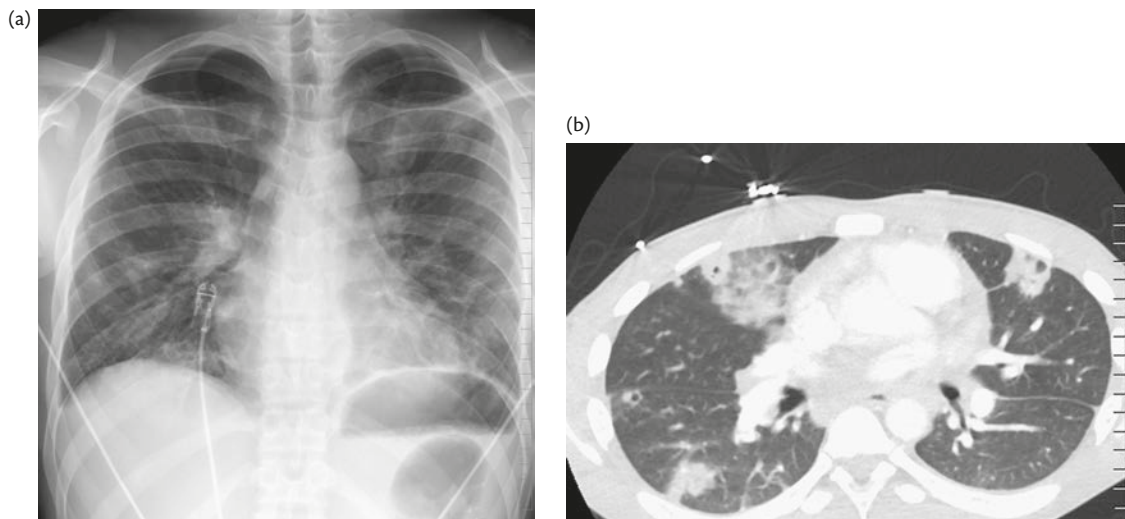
Case 6. (a) X-ray; (b) CT scan.
